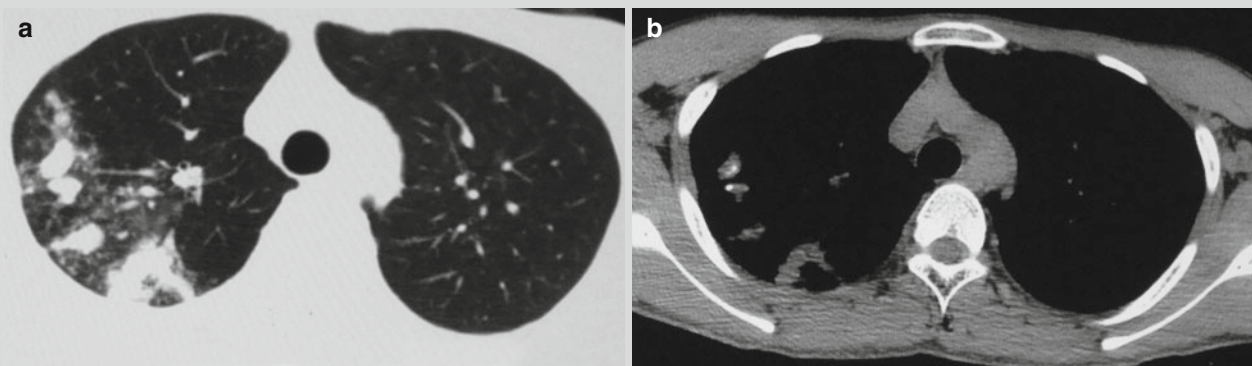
Infiltrative pulmonary TB. (a, b) CT scanning demonstrates spots of small nodular and small patches of shadows at the right upper lung lobe and calcification in the lesions at the apical segment of the right upper lung lobe
